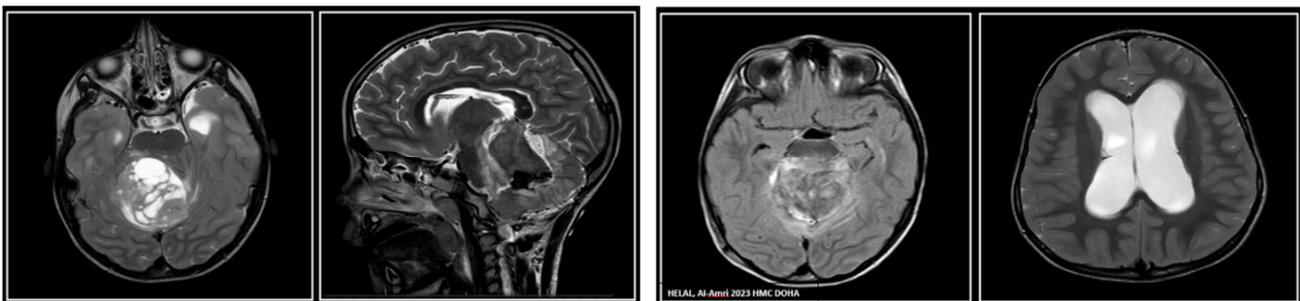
MRI of brain showed a posterior fossa mixed cystic-solid mass lesion centred on the right cerebellar hemisphere medially extending into middle cerebral peduncle and superior along the vermis where it occupies the quadrigeminal and right ambient cisterns. It measures 5.1 x 5.0 x 4.6 cm.
